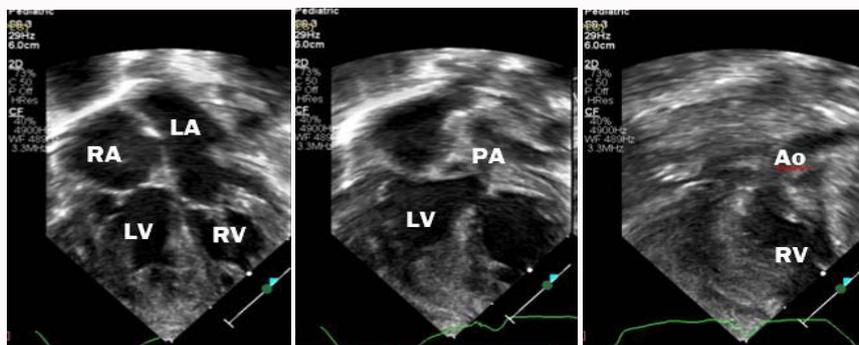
Echocardiography showed CCTGA: The right AV valve insertion higher than the left AV valve, and the chordae attached to the free wall (typical for mitral valve) with smooth Left Ventricle (LV) where the main Pulmonary Artery (PA) originated. Beside had lower insertion the left AV valve chordae attached to the septum, (typical for tricuspid valve) with coarse Right Ventricle (RV) where the Aorta (Ao) originated.
